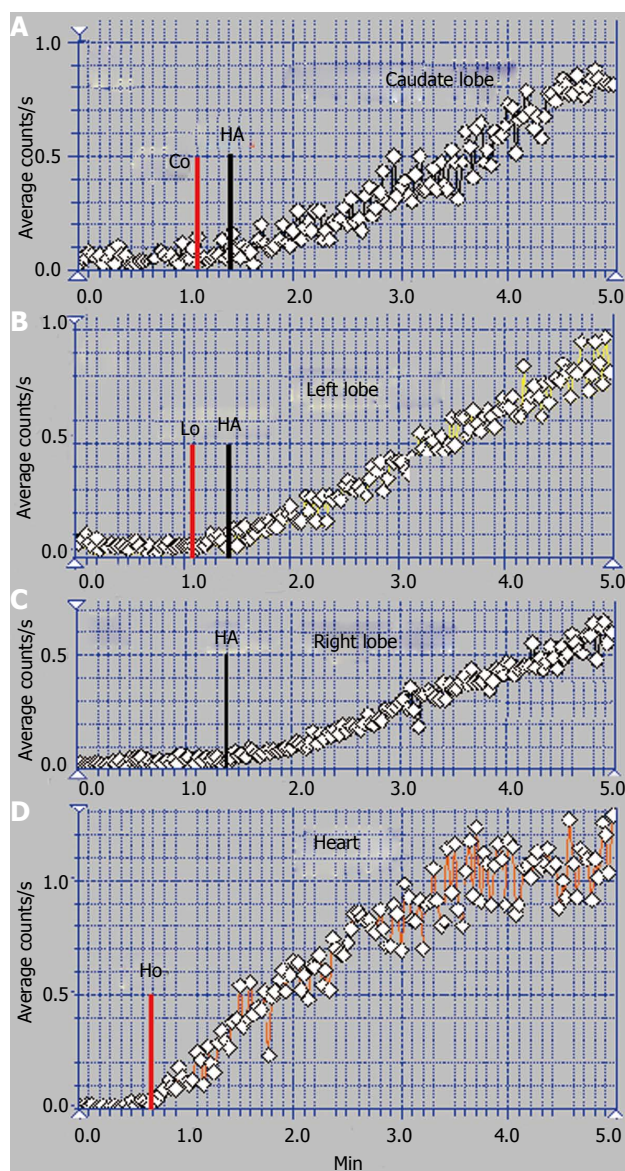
Per-rectal portal scintigraphy in Budd-Chiari syndrome with old obstruction of the middle and right hepatic veins also followed by old obstruction of the left hepatic vein. A: Caudate lobe curve; B: Left lobe curve; C: Right lobe curve; D: Heart curve.
